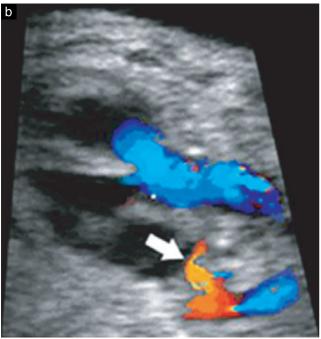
(a) Cross-sectional view of the fetal thorax, at the level of the great arteries, showing the 'flying seagull' appearance of the branch pulmonary arteries (thick arrows). The main pulmonary artery stops before reaching the outflow tract (thin arrow). AO, aorta. (b) Color Doppler showing one major aortopulmonary collateral artery (arrow) arising from the descending aorta.
